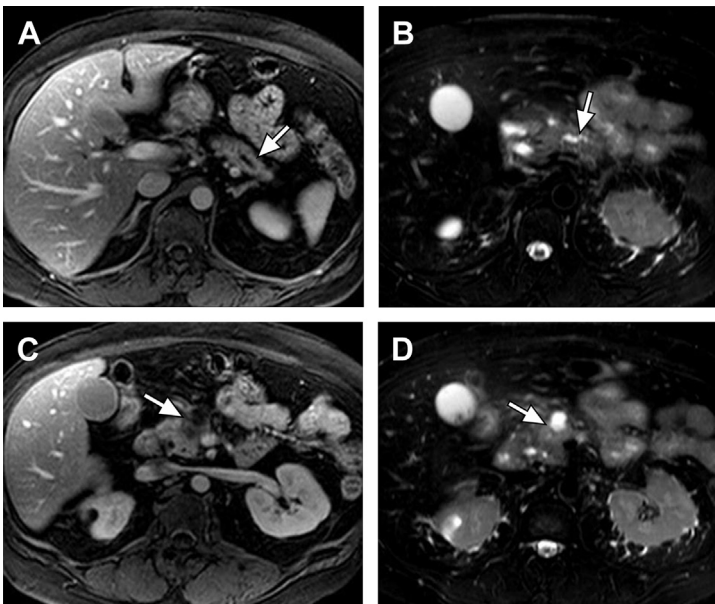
Pancreatic adenocarcinoma on MRI. (A) Contrast-enhanced axial T1-weighted gradient echo with fat suppression and (B) axial T2-weighted fast spin echo with fat suppression images through the pancreas demonstrate dilated pancreatic duct in the distal body (arrow) concerning for proximal obstructing lesion. (C, D) Similar images at a lower level demonstrate a focal mass in the pancreatic head showing low signal intensity on the T1-weighted images (arrow in C) and high signal intensity on the T2-weighted images (arrow in D).
